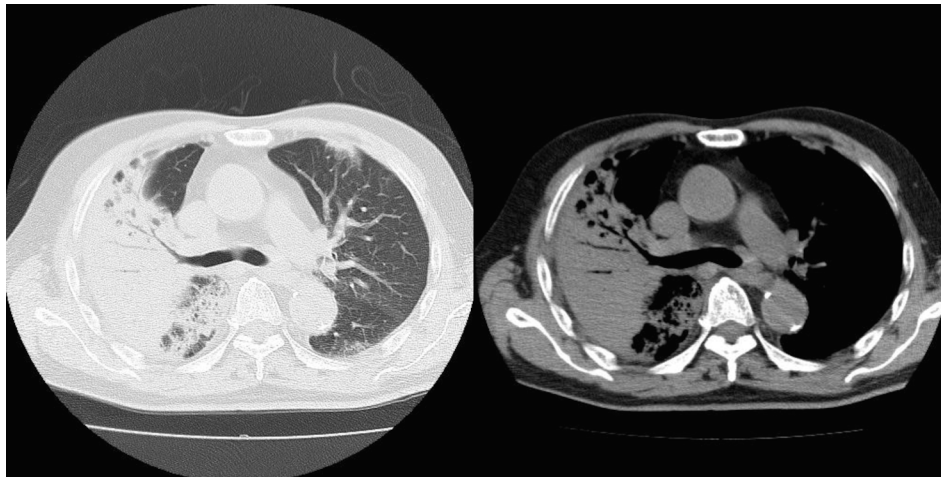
Computed tomography (CT) images show an area of consolidation with air bronchogram in the right upper lung, ground-glass opacity in the left lung, and enlarged mediastinal lymph nodes.
